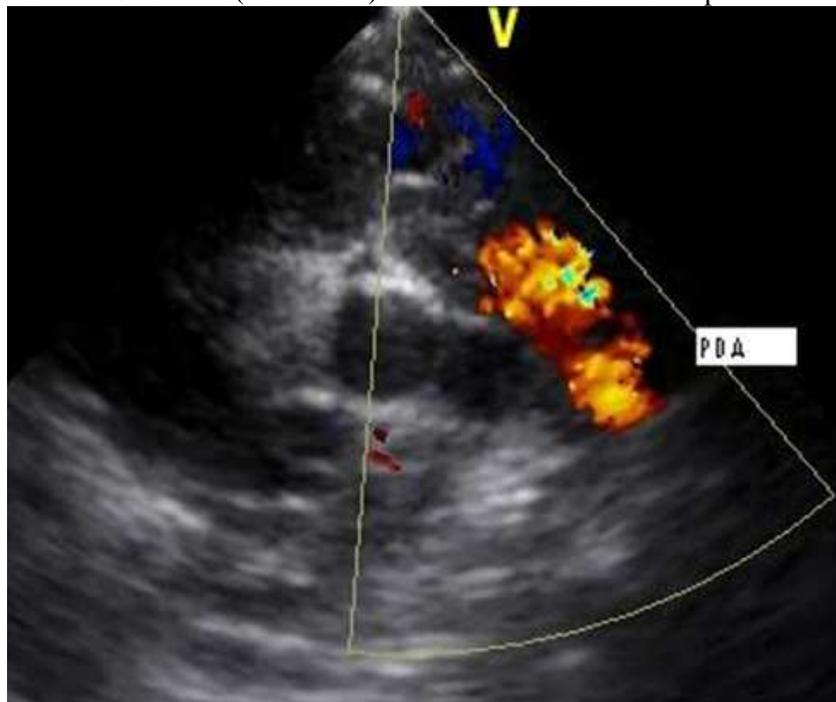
Parasternal Short axis(color flow) view shows the small size patent ductus arteriosus.
